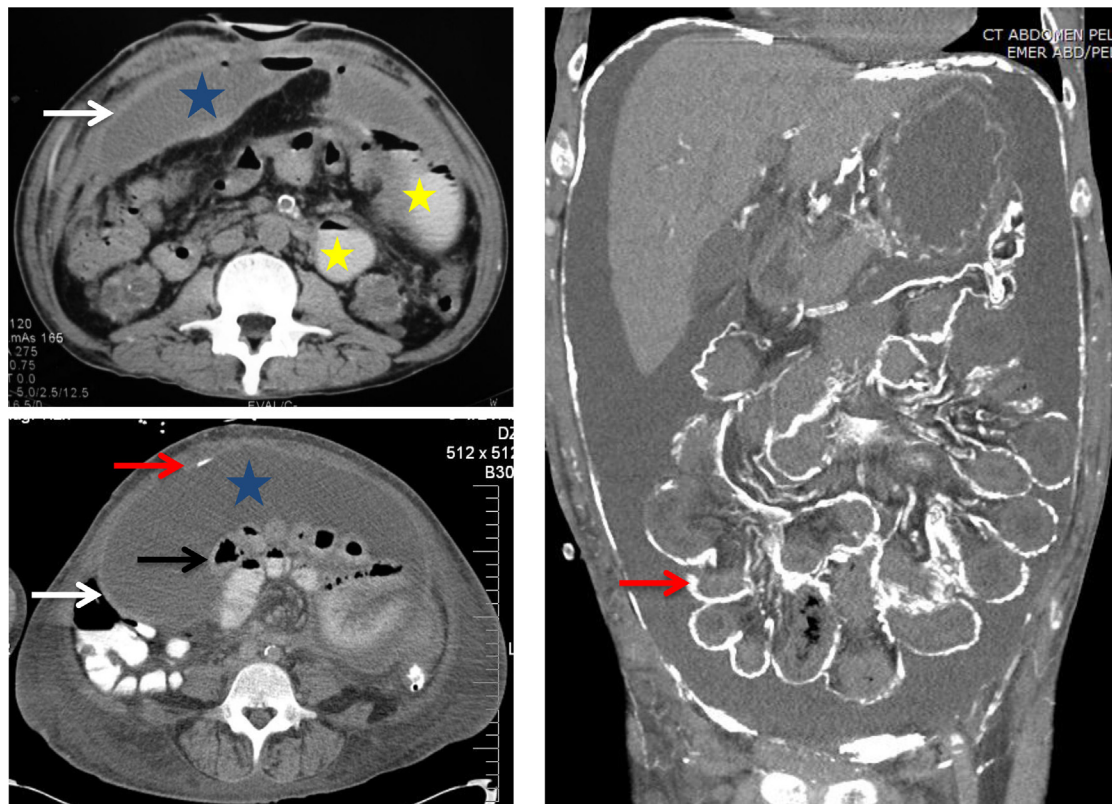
Characteristic computed tomographic findings of encapsulating peritoneal sclerosis: peritoneal thickening (white arrow), peritoneal calcification (red arrow); loculated fluid collection (blue star), dilated loops of bowel (yellow star), and tethered small bowel loops (black arrow). Top and bottom left panels courtesy of Dr S.F. Cameron.
